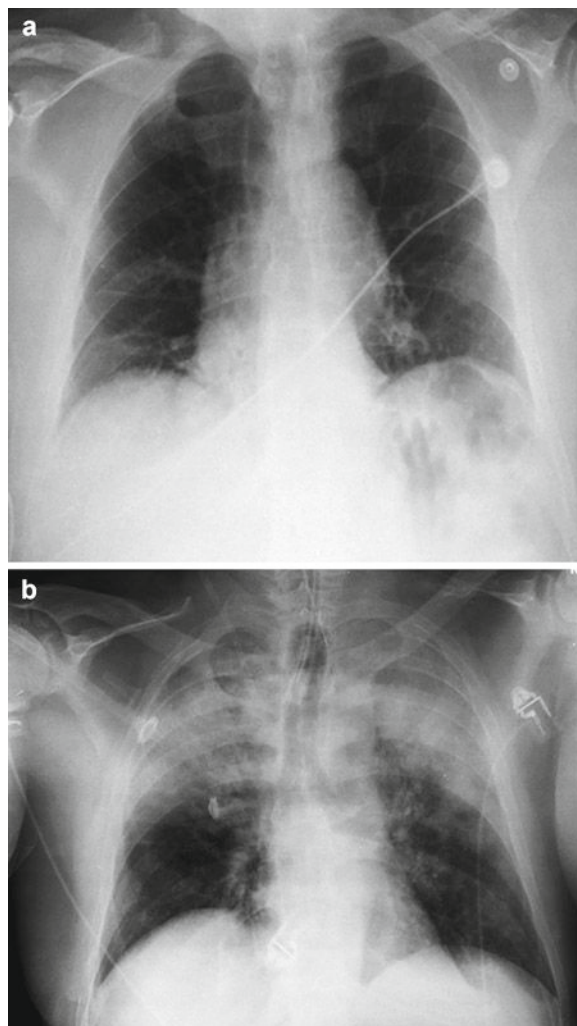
A chest radiograph of a patient with fatal TRALI. (a) Radiograph taken prior to surgery. This X-ray shows normal cardiomeastinal silhouette, bilateral basilar atelectasis, and low lung volumes, but there is no evidence of pleural effusion, focal consolidation, or pneumothorax. (b) Radiograph taken at the time TRALI was identified. This X-ray demonstrates extensive bilateral areas of consolidation in the mid and upper lobes of the lung consistent with aspiration or edema with a normal cardiac silhouette, new since the previous examination earlier on the same day. Radiographs from N Leeborg and LK Boshkov, Department of Pathology, School of Medicine, Oregon Health Sciences University, Portland OR
